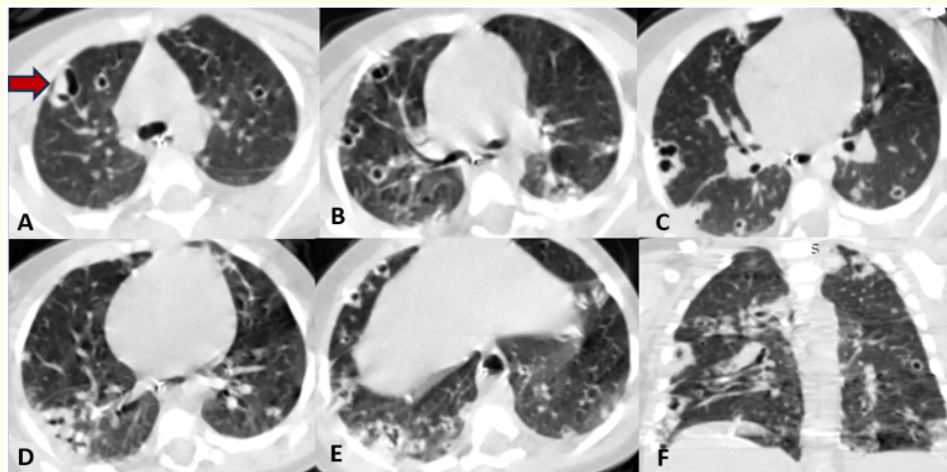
Chest CT findings in a 9-month-old infant with severe *Staphylococcus aureus* infection. Axial lung-window images (A-E) and coronal reconstruction (F) demonstrate multiple bilateral pulmonary nodules, several showing central cavitation and predominantly peripheral distribution, consistent with septic pulmonary emboli, associated with multifocal areas of parenchymal consolidation and a small-volume pleural effusion. The apical pulmonary lesion, initially presenting as a focal consolidation, subsequently underwent cavitation, reflecting the necrotizing nature of the pulmonary involvement (Red arrow).
